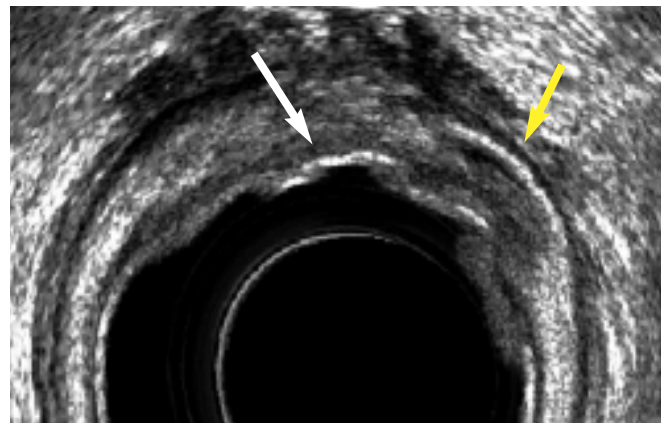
Endoanal ultrasound of a rectal cancer (white arrow) which has breached the muscularis propria (yellow arrow) and is invading into perirectal fat or serosa and is therefore staged as uT3.
